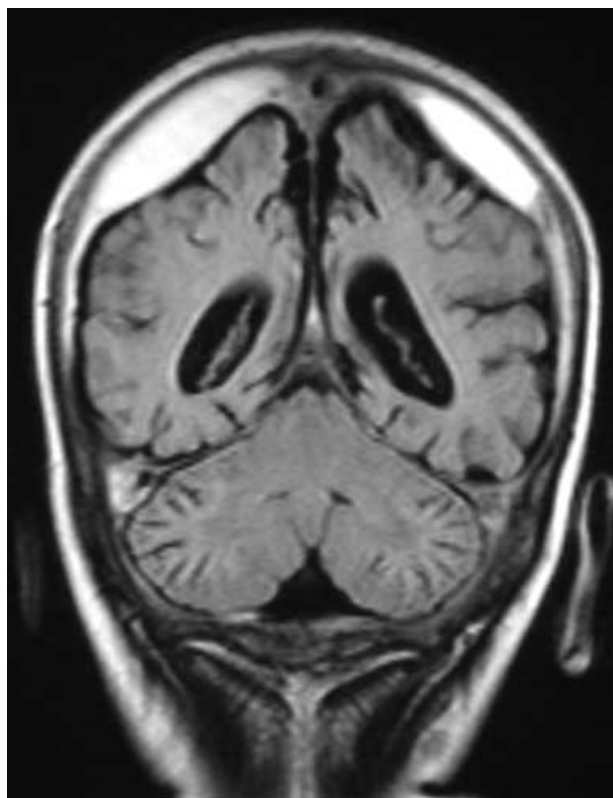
Magnetic resonance imaging, fluid-attenuated inversion recovery, coronal view: Bilateral subdural hematoma and atrophy of the parietal lobes.
